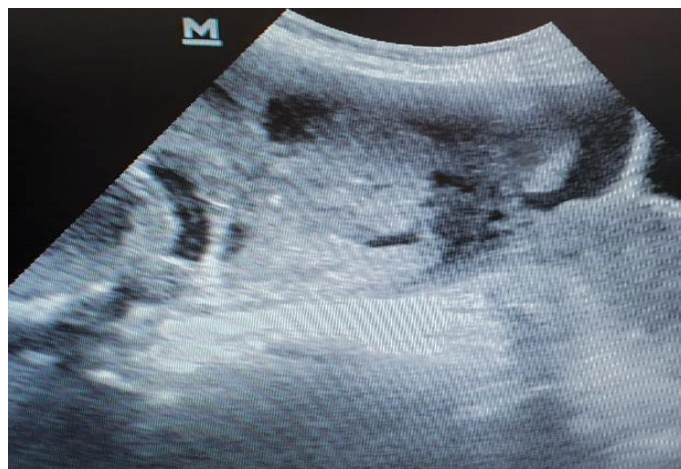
Ultrasound image of a ruptured rudimentary horn pregnancy at 23 weeks of gestation
